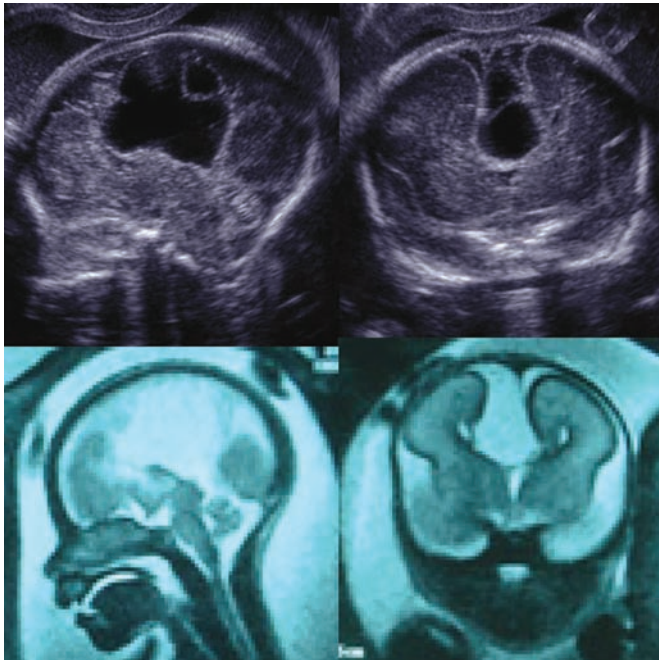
Ultrasound and MR images of interhemispheric cyst at 24 weeks of gestation. (Upper left) Ultrasound median section. (Upper right) Ultrasound anterior coronal section. (Lower left) MR median section. (Lower right) MR anterior coronal section. Cystic lesion exists between hemispheres. Intracystic cyst is visible in the ultrasound images.
